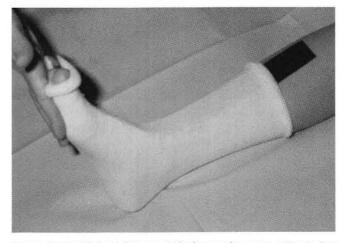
Padded stockinette applied over the x-ray strips to just beyond the desired length distally and proximally.
